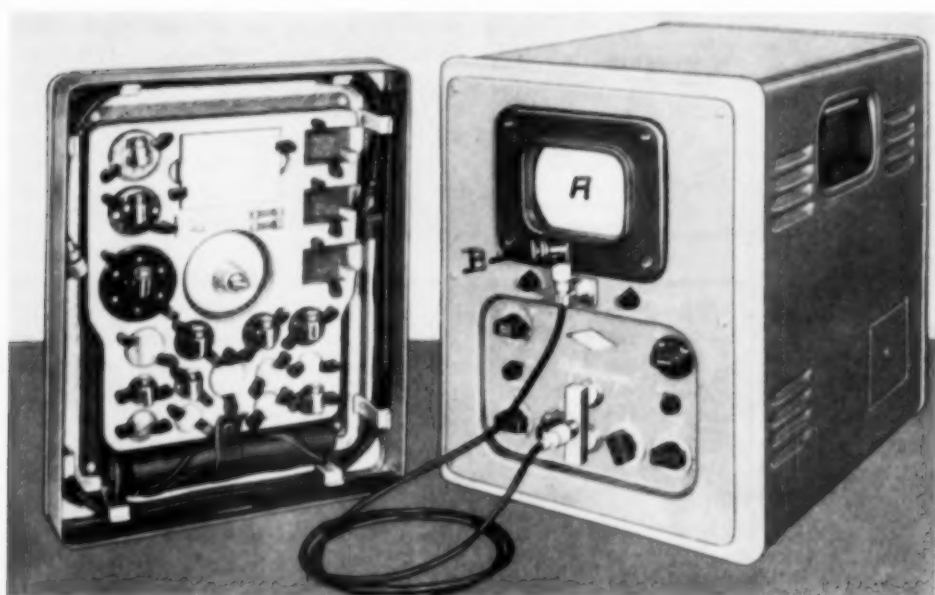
(Mundt and Hughes). Type UR Reflectoscope equipped for double-searching unit testing and provided with a delayed sweep feature (taken from manual, *Ultrasonic Testing*, published by Sperry Products, Inc.). (A) Cathode-ray screen on which the ultrasonic reflections are projected. (B) Crystal vibrator or searching unit (transducer) which converts electric impulses into ultrasonic waves, and also receives the reflected "echoes" of the ultrasonic waves for transmission as electric impulses to the cathode ray tube.
